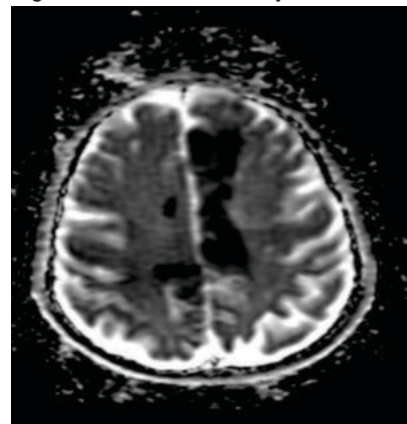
DWI images showing areas of diffusion restriction with corresponding low values on ADC maps
